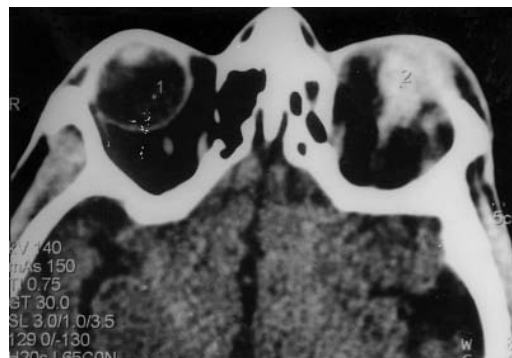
Axial CT-scan showing air in both orbits and an atrophic, shrunken eyeball on the left side.
